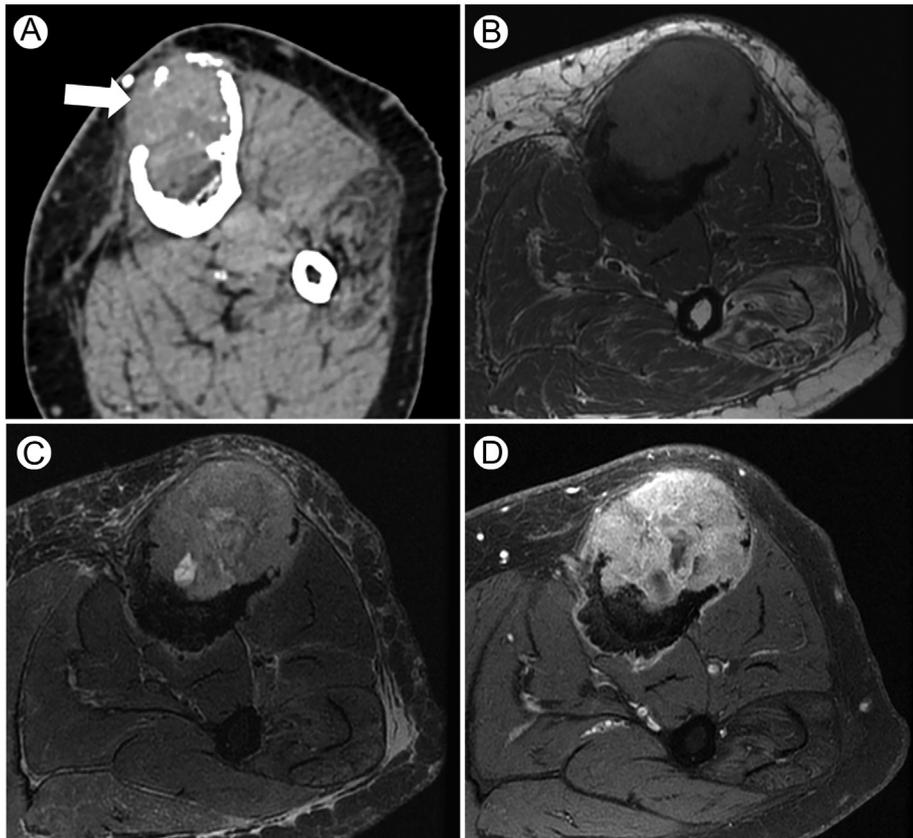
A, Axial CT without contrast confirms an area of cortical destruction and a small soft tissue mass (arrow). Axial T1-weighted (B), T2-weighted fat-saturated (C), and postgadolinium fat-saturated (D) images show the intramedullary involvement.
